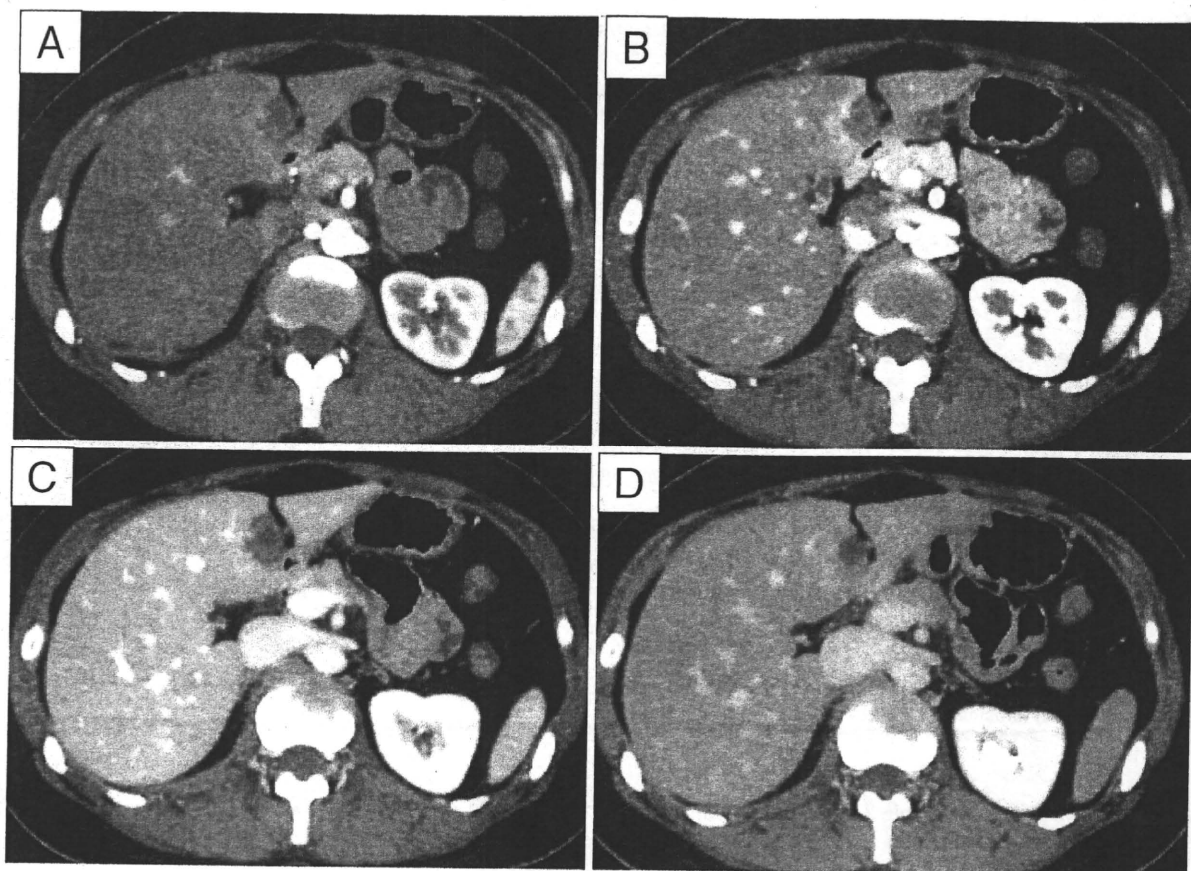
Abdominal contrast CT. Scans were obtained during injection of 100 ml of contrast medium at 3.0 ml/sec. After the start of the injection, precontrast CT was initiated at 13 seconds (A), hepatic arterial CT at 24 seconds (B), and portal venous CT at 65 seconds (C), venous CT at 180 seconds (D). This study shows low density area with gradual enhancement from the margin. The lesion was suspected to be metastasis from pulmonary epithelioid hemangioendothelioma (PEH) in the liver.
